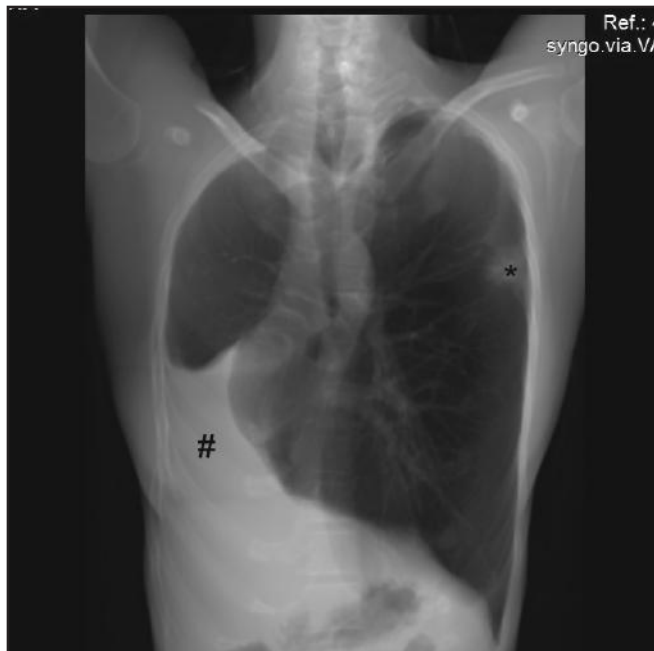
Chest radiograph showing radio opaque right hemithorax with herniation of left lung. Small consolidation is seen in left upper zone
